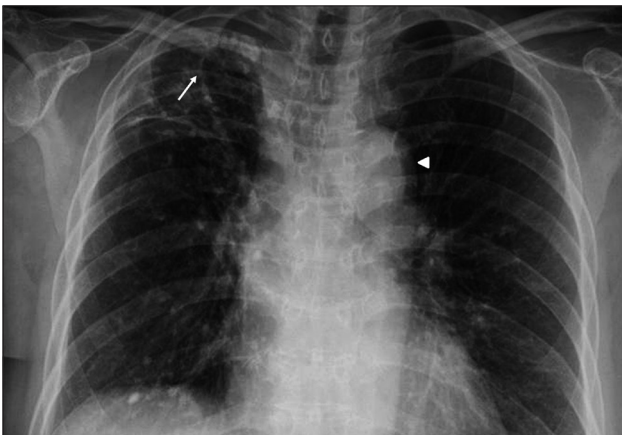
Chest radiograph shows multiple confluent irregular opacities (arrow) in right upper lobe. There are no remarkable findings in hilar region with shadow of aortic arch (arrowhead).
